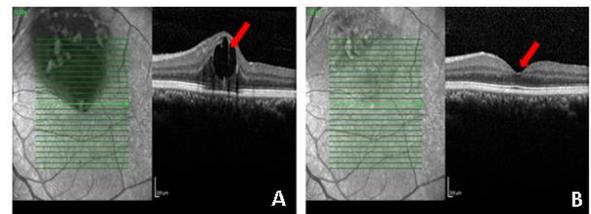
Optical computed tomography (OCT) showing cystoid macula oedema at first presentation (red arrow) (A) and completely resolved macular oedema (red arrow) at 1 month after completing the third injection of intravitreal ranibizumab (B).
